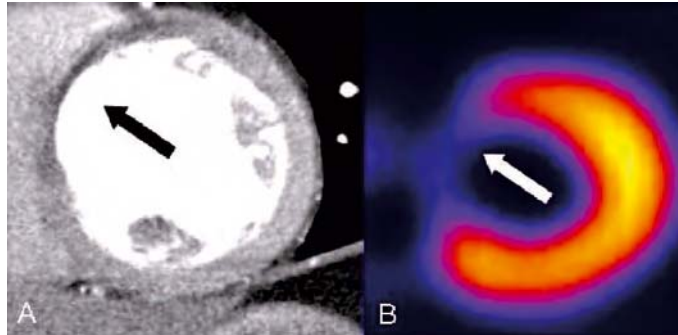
Example of a patient with anteroseptal myocardial infarct. Panel A: MSCT short-axis image with hypo-enhanced area anteroseptal (black arrow). Panel B: SPECT short-axis image with perfusion defect anteroseptal (white arrow).
